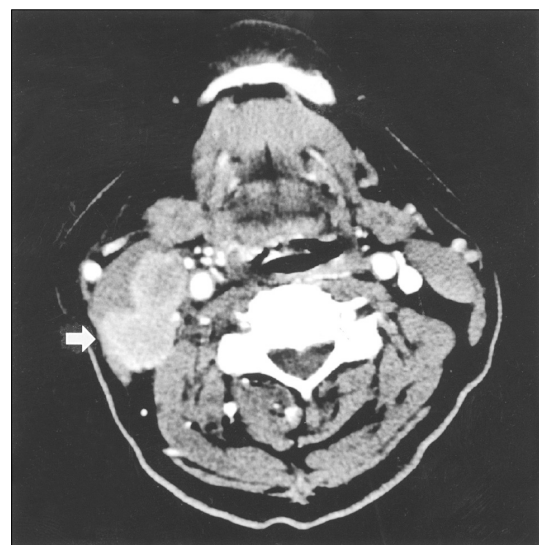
The delay image of postcontrast enhanced neck CT scans at the hyoid level shows two chained enlarged lymph node (white arrow) just below the right sternocleidomastoid muscle. The extranodal extension and infiltration of sternocleidomastoid muscle are strongly suspected.
